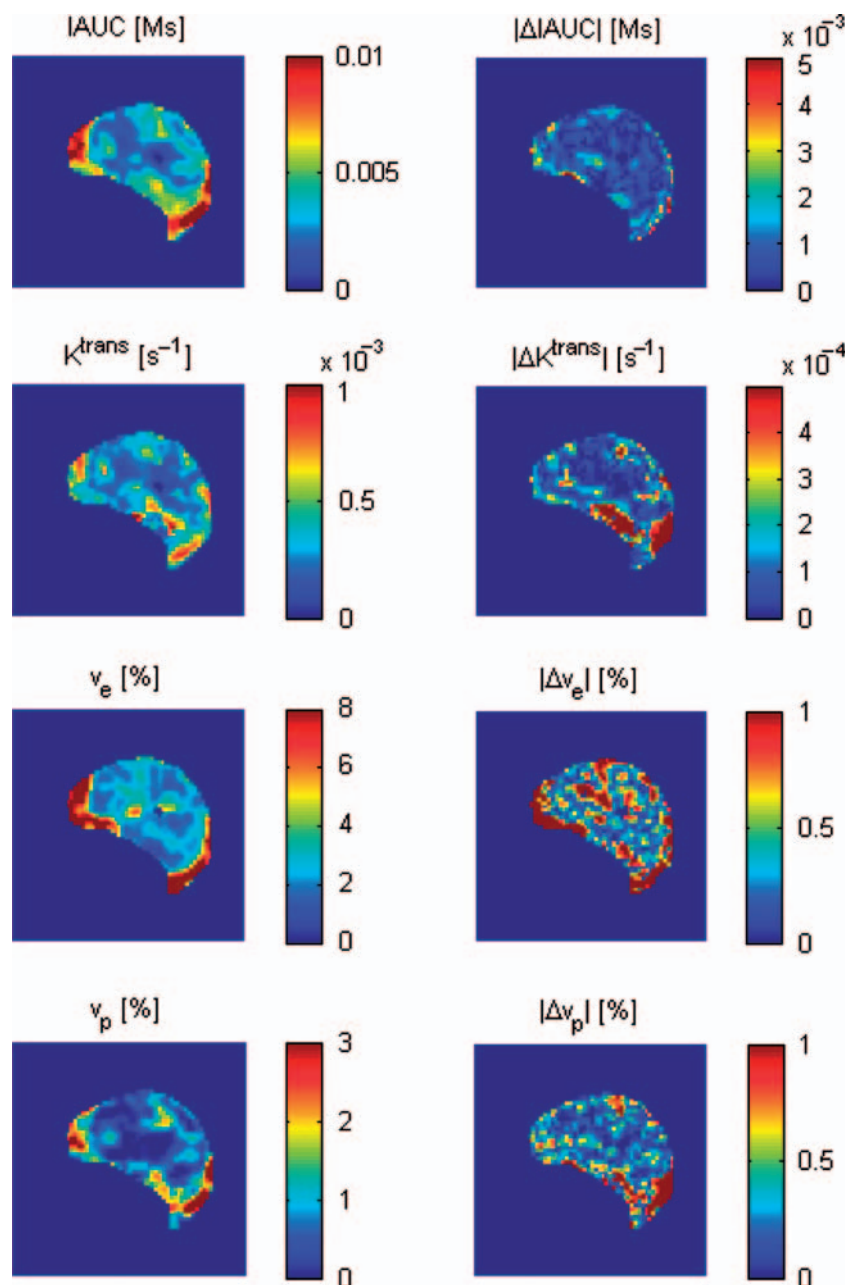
DCE-MRI parametric maps for the same control tumour as shown in Figure 1. Initial maps and difference maps for the two DCE-MRI scans are shown.
